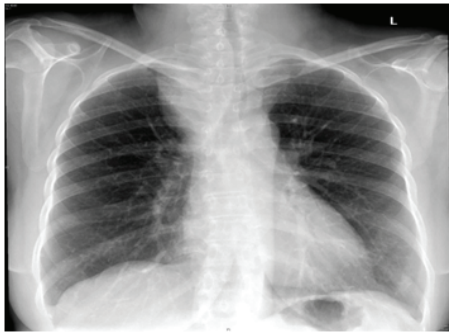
Chest X-ray showing large superior mediastinal mass, soft tissue density lesion, mainly at right side compressing the trachea to the left side.
